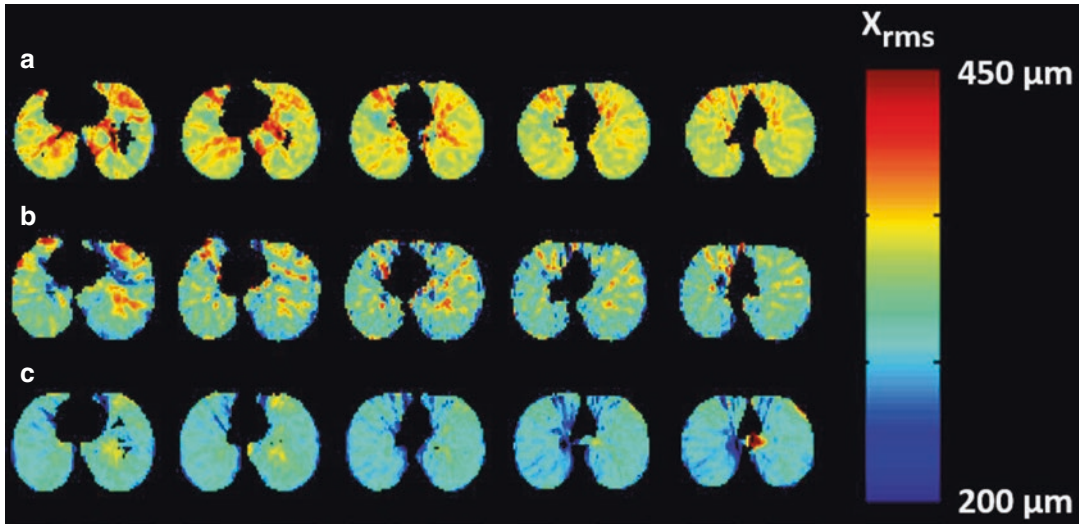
Example of the evaluation of small airway dimensions using HP ³He MRI diffusion imaging. X_{rms} lung maps are shown for three subjects: (a) a healthy 10-year-old child, (b) a 9-year-old child with asthma, and (c) a
